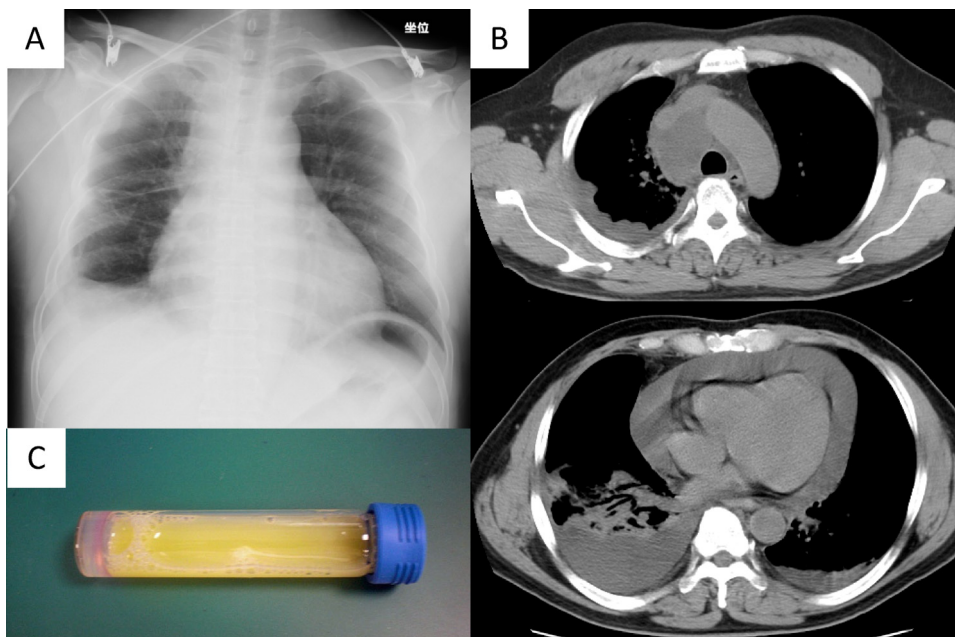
Diagnostic findings at admission. A) Chest radiography revealed an enlarged cardiac silhouette with signs of fluid in the right hemithorax. B) Chest computed tomography revealed fluid collection in the upper mediastinum with pleural and pericardial effusion. (C) Yellowish-white fluid was obtained at pericardiocentesis.
